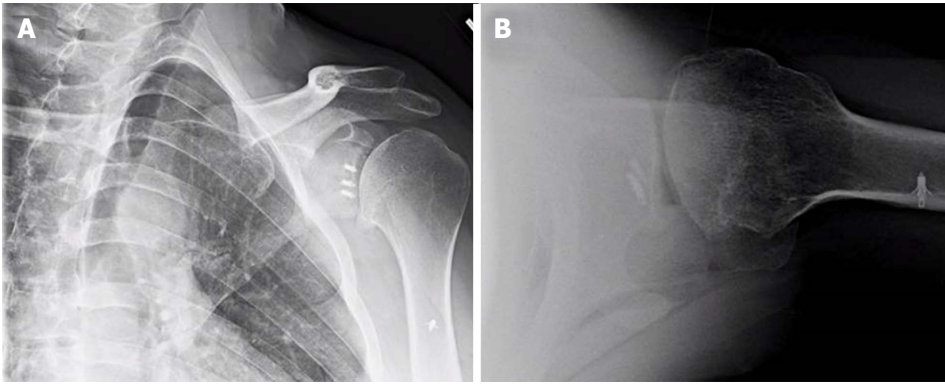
Anteroposterior (A) and lateral (B) X-rays of a 39-year-old male with dislocation arthropathy status post instability procedure with metal anchors.
